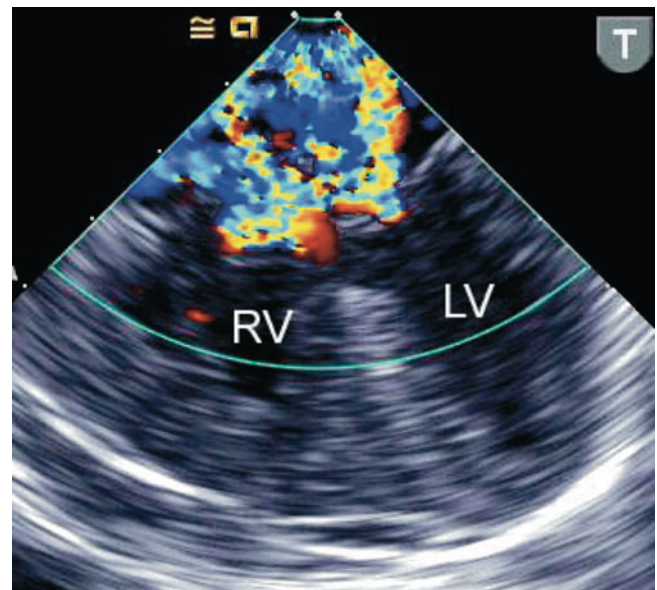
The image shows preoperative color flow information obtained in a mid esophageal four chamber view using a pediatric biplane transesophageal probe in a small infant with a complete atrioventricular septal defect. Significant regurgitation is depicted from both the left and right atrioventricular valvar components, during systole. LV left ventricle, RV right ventricle
